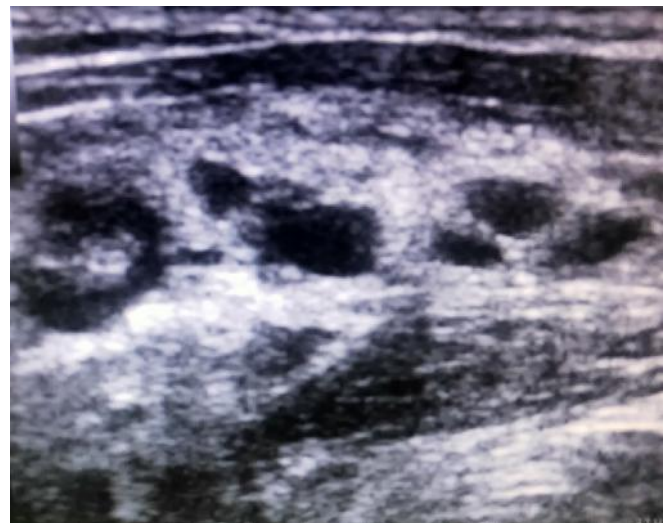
Venous malformation in arm as seen in B mode of ultrasound
